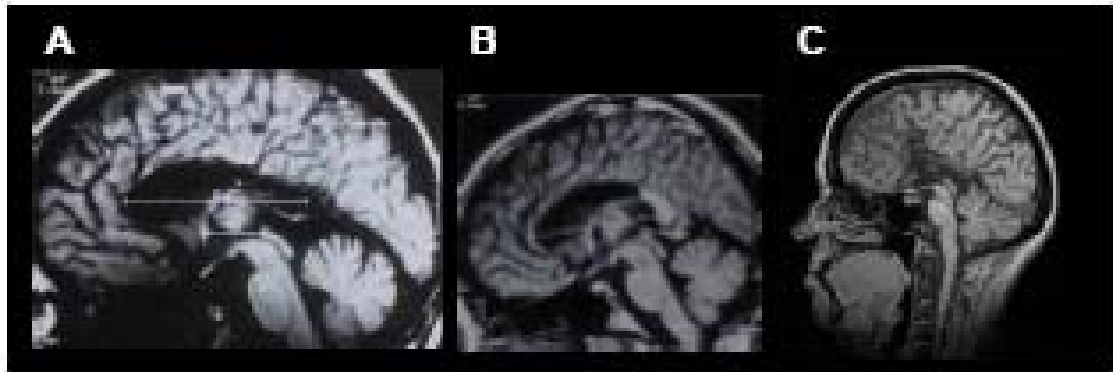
MRI of A) total split-brain individual, B) partial split-brain individual and C) callosal agenesis individual.
